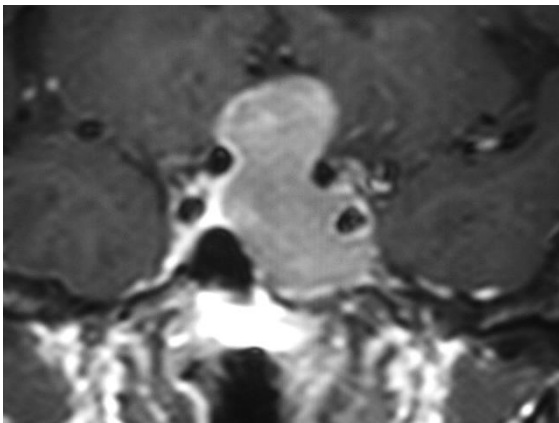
MRI (coronal view) of a macroadenoma with suprasellar and left cavernous sinus invasion
